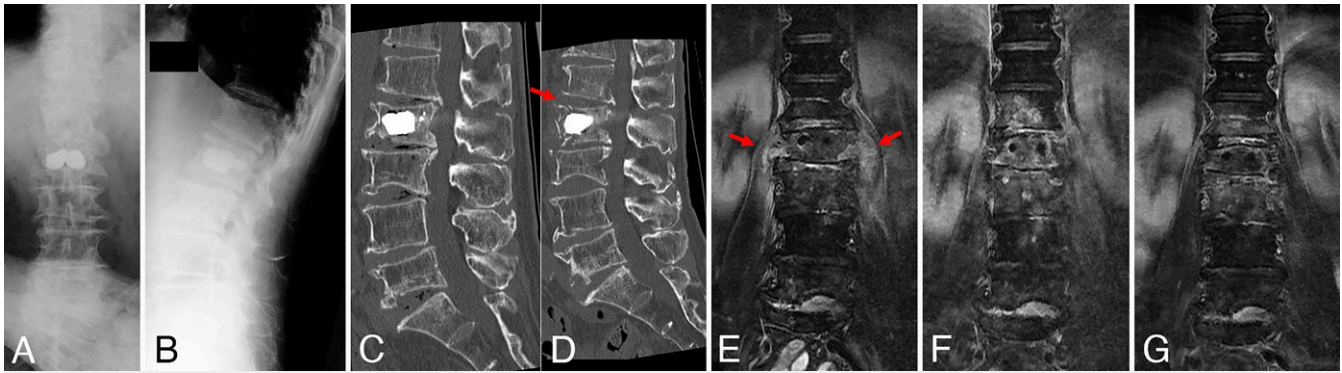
A–D: Postoperative radiography and CT immediately after BKP (A and B), 5 days after BKP (C), and 41 days after BKP (D). E–G: Postoperative MRI 26 days after BKP (E), MRI 40 days after BKP (F), and MRI 92 days after BKP (G). Postoperative CT revealed the fracture of the upper endplate of the L2 vertebral body, which is compatible with spondylitis (red arrow). Postoperative MRI revealed a bilateral psoas abscess (red arrow). The psoas abscess reduced conservatively with antibacterial agents.
